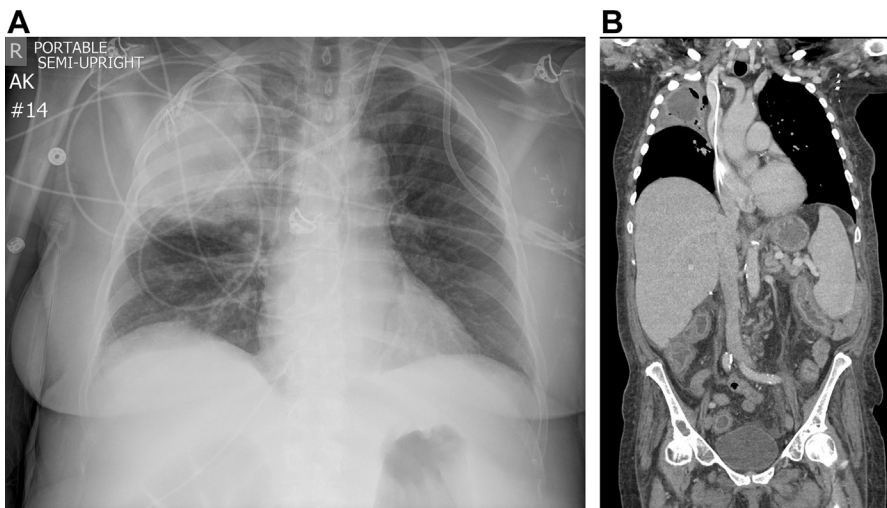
Chest radiograph (A) and CT (B) in a patient with *Legionella pneumophila*. Radiograph demonstrates focal right upper lobe consolidation. Follow-up chest CT demonstrates hypoattenuating consolidation with internal gas compatible with necrosis. Urine *Legionella* antigen was positive at the time of radiographic imaging, allowing the radiologist to corroborate the imaging findings with test results.
